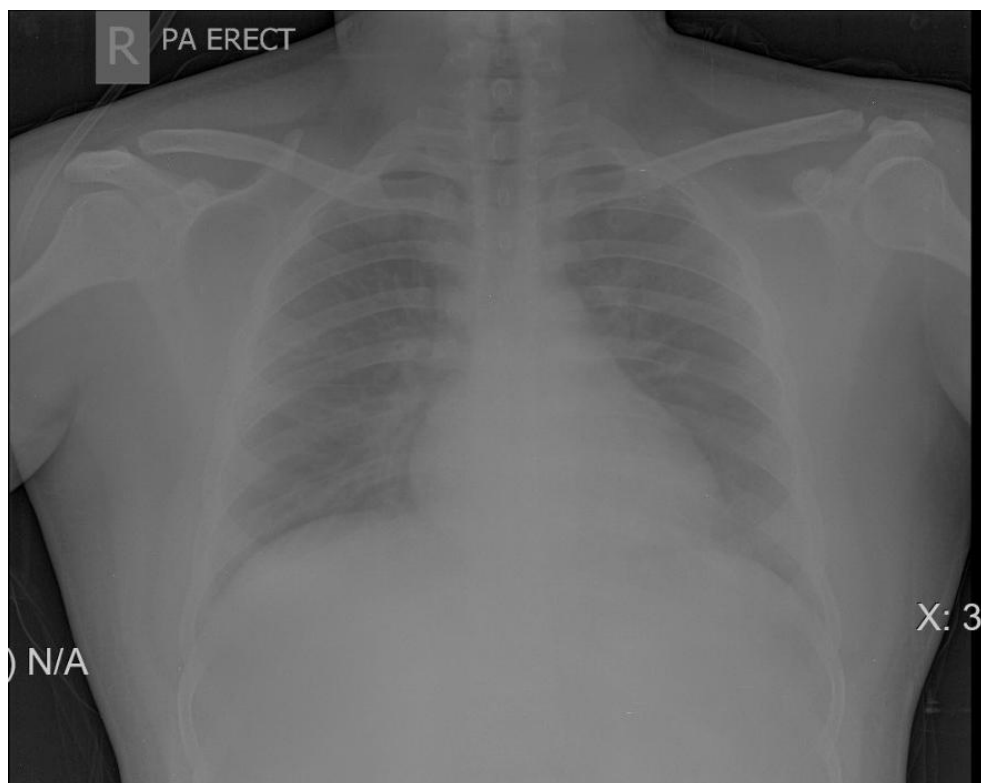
Thorax X-ray Show no deformity
